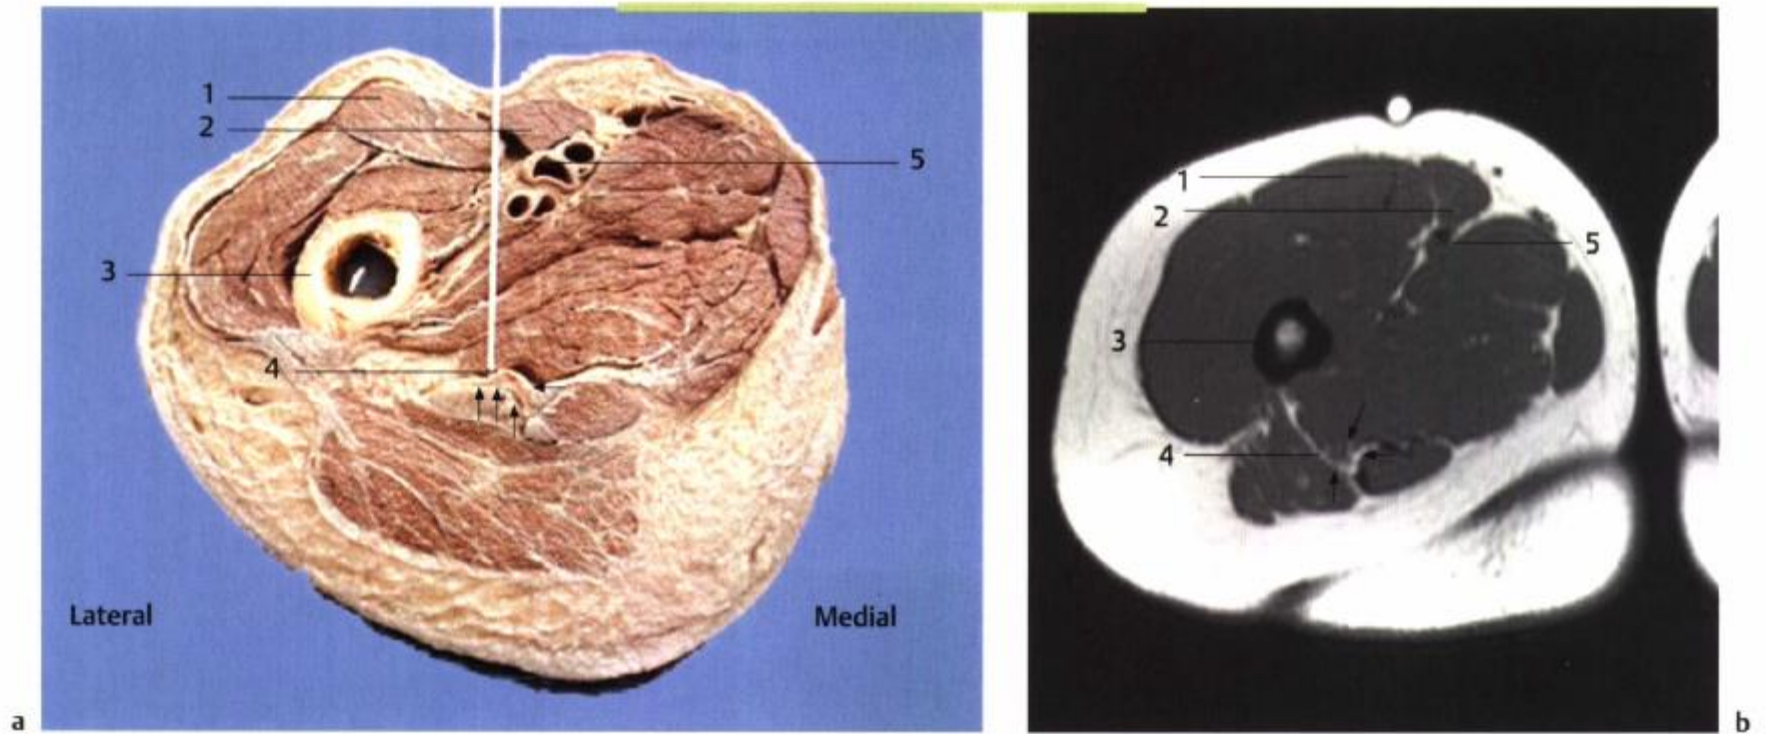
Anterior sciatic nerve block using the muscle gap between rectus femoris and sartorius for orientation: anatomical cross section and MRI at the level of the puncture. a Right leg, seen from below, b MR image, right thigh.
